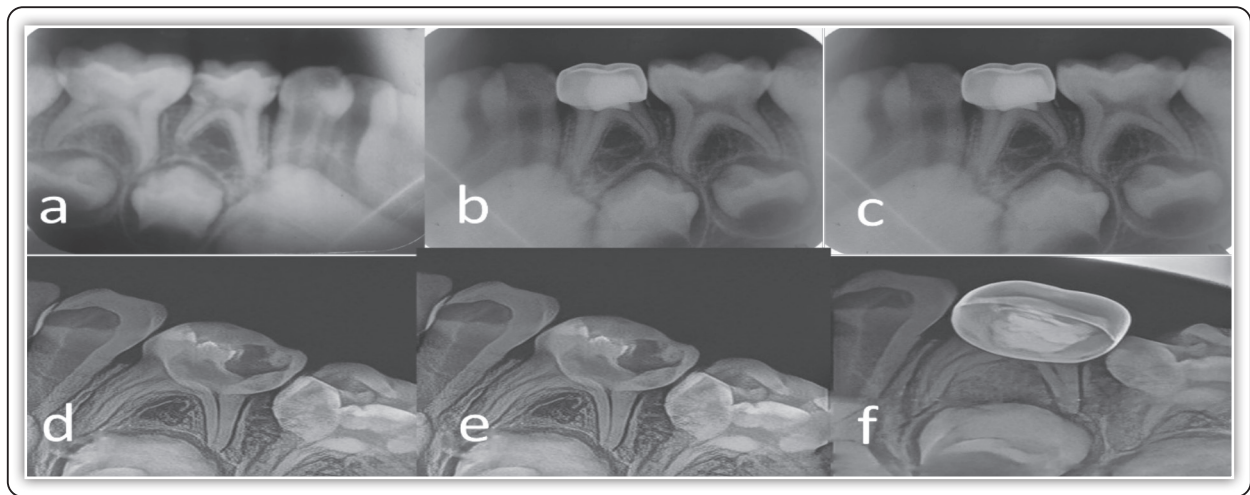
For FS & CTZ: a, Radiographic evaluation after 1 month evaluation, b, Radiographic evaluation after 3 months, c, Radiographic evaluation after 6 months. For FS & CTZ f, Radiographic evaluation after 1 month evaluation, b, Radiographic evaluation after 3 months, c, Radiographic evaluation after 6 months.
